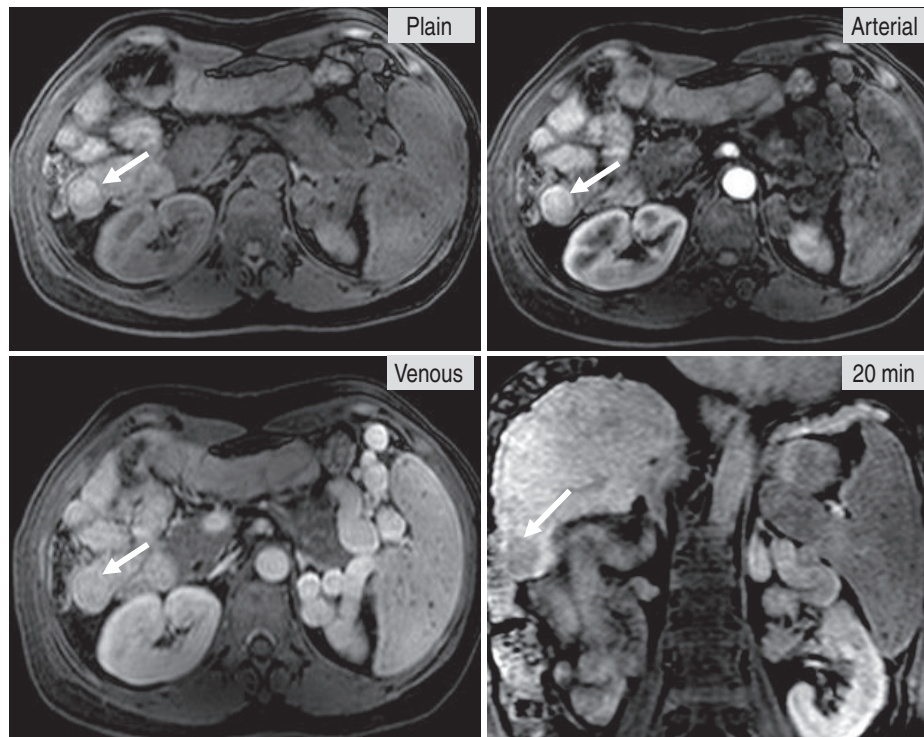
MRI with EOB-primovist contrast agent shows arterial enhancement, but iso-venous washout, which is not diagnostic for HCC, based upon the AASLD guideline. However, at 20 min hepatobiliary (HB) phase, the nodule shows no uptake of primovist. Based upon the Japanese guideline, a combination of arterial enhancement with no primovist uptake is characteristic for HCC regardless of venous phase.
